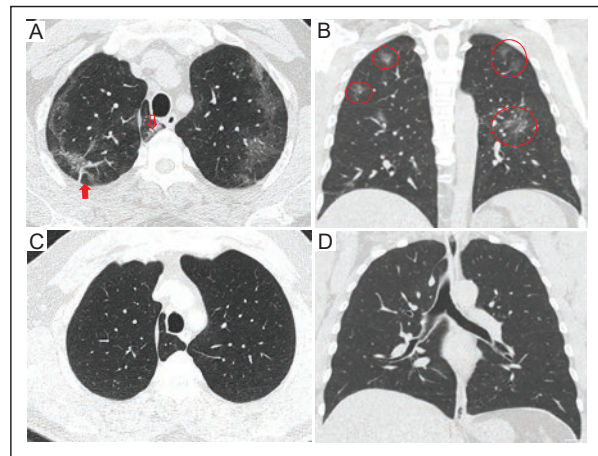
Chest CT of a 51-year-old male diagnosed with COVID-19. A: coronal and B: axial baseline images showing an azygos lobe with interstitial impairment (open arrow) and subpleural atelectasis in the right lung (solid arrow), along with pleural thickening in the fissures (solid arrows) and patches of ground-glass opacity with peripheral and bilateral distribution (circles). C: coronal and D: axial follow-up images obtained 19 months after the initial infection, demonstrate complete remission of the findings. CT: computed tomography; COVID: coronavirus disease.
